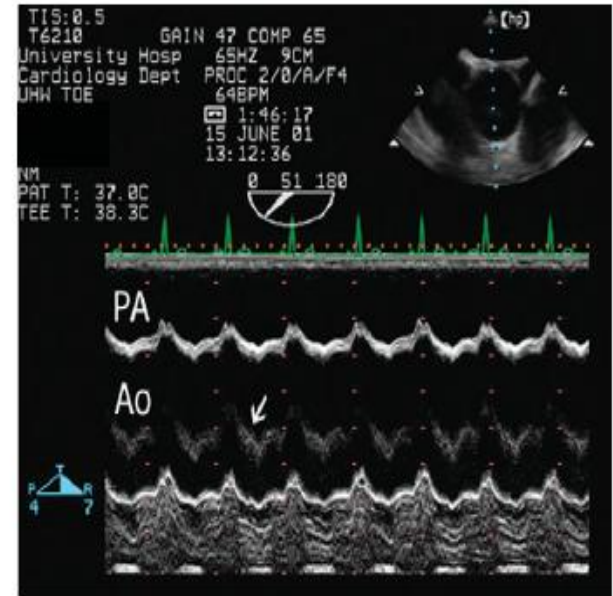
Reverberation artefact seen by M-mode transoesophageal echocardiography. An apparent linear echo in the aorta is seen (white arrow)—it mirrors the motion of the echo bright posterior aortic wall, is twice the distance from the probe, and has twice the amplitude of movement. PA, pulmonary artery; Ao, aorta.
